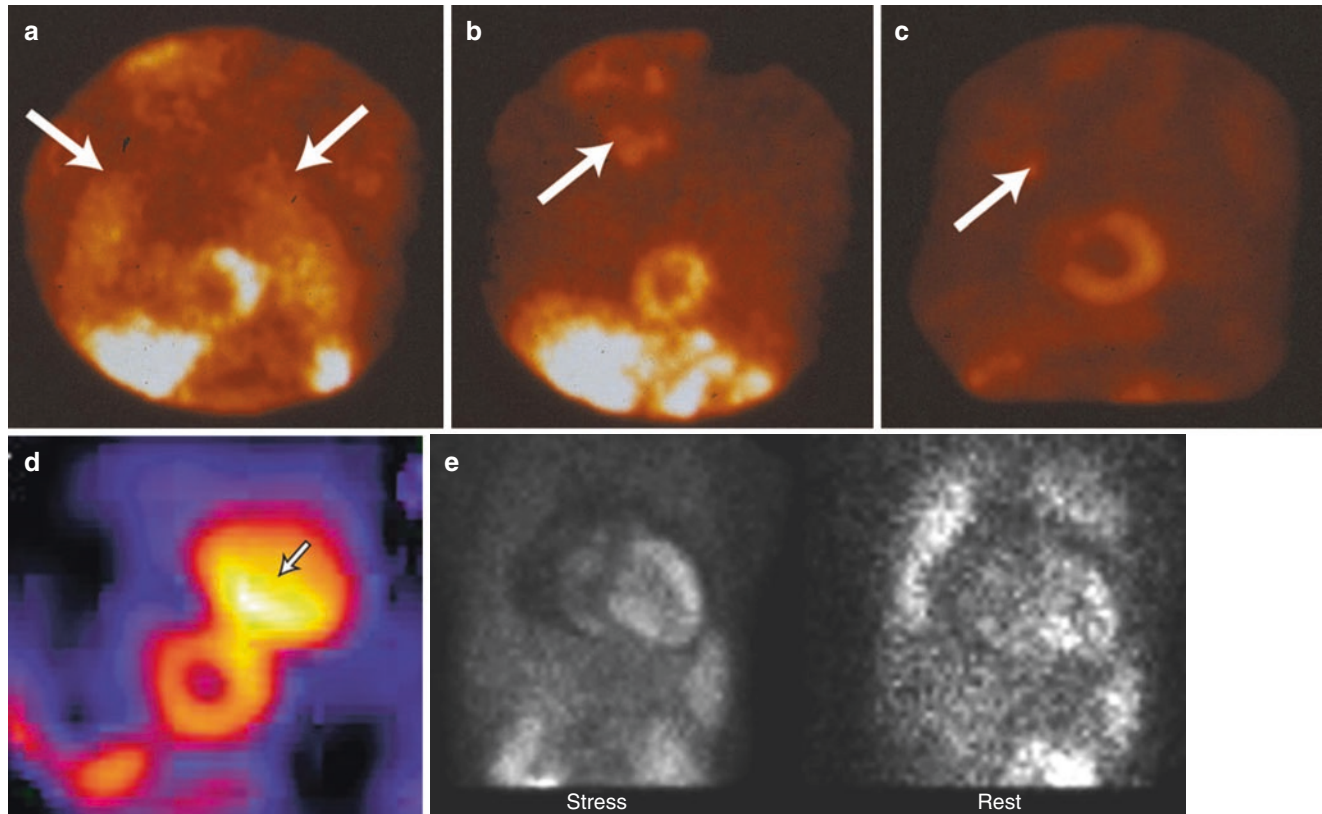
Clinically relevant extracardiac activity. (a) Increased lung uptake (*arrows*) is associated with extensive coronary artery disease and an adverse prognosis. In patients with extensive myocardial ischemia and/or left ventricular dysfunction, it is likely that increases in the left atrial and pulmonary capillary wedge pressures slow the pulmonary transit of the radiotracer, thereby allowing more time for extraction or transudation of the radiotracer into the interstitial spaces of the lung. Lung uptake has been more extensively validated with ^{201}Tl than $^{99\text{m}}\text{Tc}$ perfusion tracers. Because of differences in the biodistribution and clearance of ^{201}Tl and $^{99\text{m}}\text{Tc}$ perfusion tracers, thallium images are acquired within a few minutes after exercise (minimal splanchnic and background activity), but the $^{99\text{m}}\text{Tc}$ -sestamibi and $^{99\text{m}}\text{Tc}$ -tetrofosmin are usually acquired 15–30 minutes after exercise and 30–60 minutes after pharmacologic vasodilation. (Liver uptake is more prominent than the heart if imaged too early.) Thus, lung uptake, even if it was present early after stress, may be missed with $^{99\text{m}}\text{Tc}$ -sestamibi and $^{99\text{m}}\text{Tc}$ -tetrofosmin because of the more delayed imaging after stress when compared with thallium. (b) An example of a patient with findings of a parathyroid adenoma (*arrow*) in stress $^{99\text{m}}\text{Tc}$ -sestamibi myocardial perfusion SPECT. The rotating planar projection images allow the visualization of noncardiac structures such as lung, breast, and the thyroid gland. An
